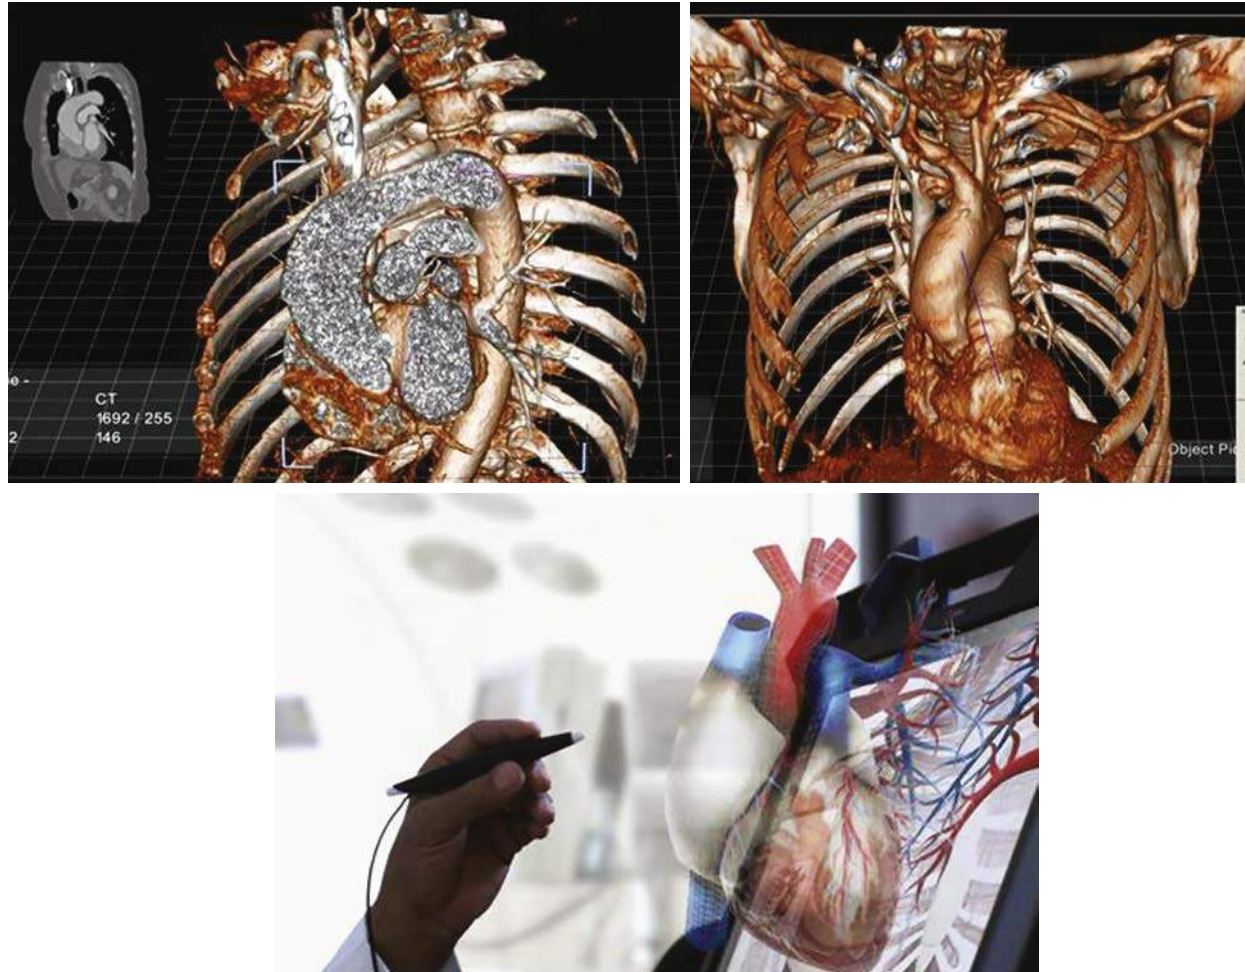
Three-dimensional (3D) holographic systems are now clinically available, such as the cardiovascular images above displayed courtesy of Echopixel Inc (Mountainview). Their True 3D software allows patient-specific anatomy in a virtual reality format that can be used and manipulated directly in the operating room or catheterization laboratory. For visualizing aortopulmonary collaterals or aortic anatomy prior to interventions, there are intuitive advantages compared with traditional flat screen computed tomography or magnetic resonance imaging.
